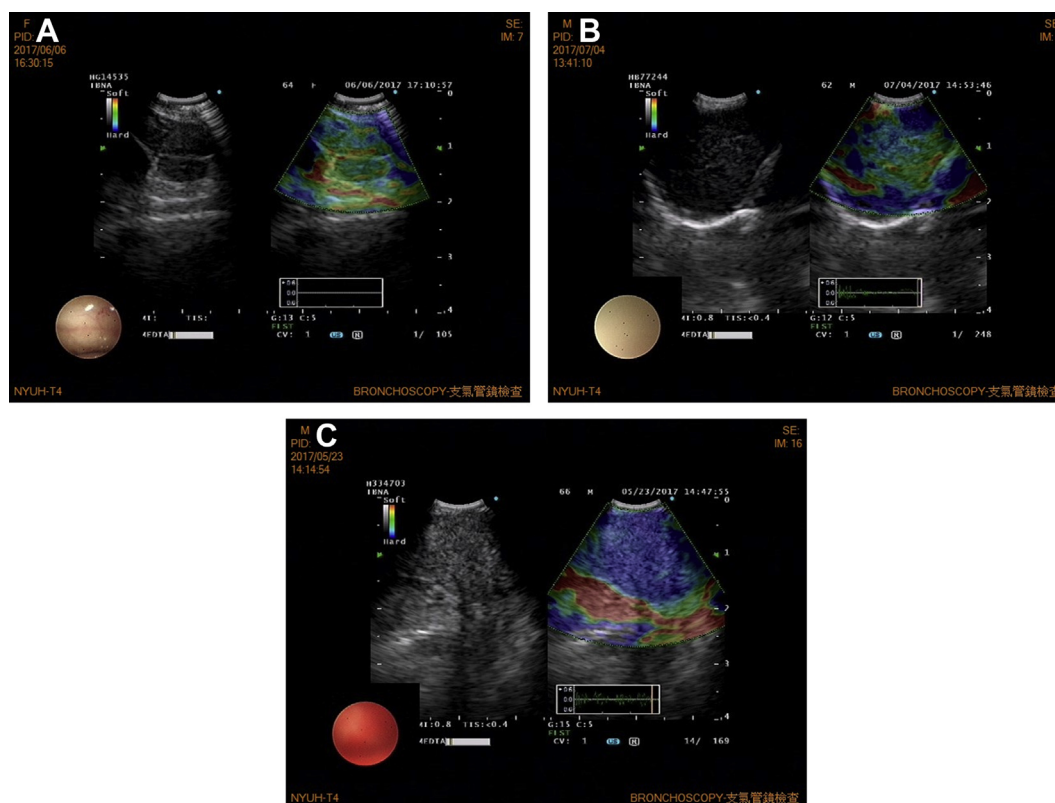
Representative lymph nodes on EBUS elastography. Panel A: Predominantly non-blue (green, yellow and red) (Type 1). Panel B: Part blue, part non-blue (Type 2). Panel C: Predominantly blue (Type 3). EBUS = endobronchial ultrasound.
